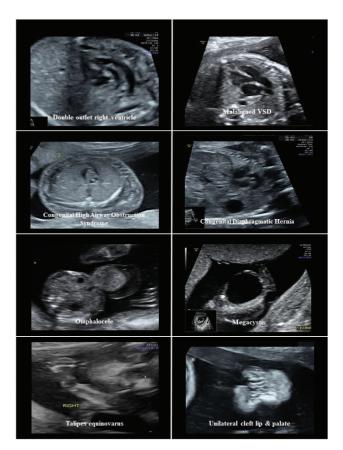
Ultrasound images of few discordant twins with various anomalies as depicted in the pictures.
